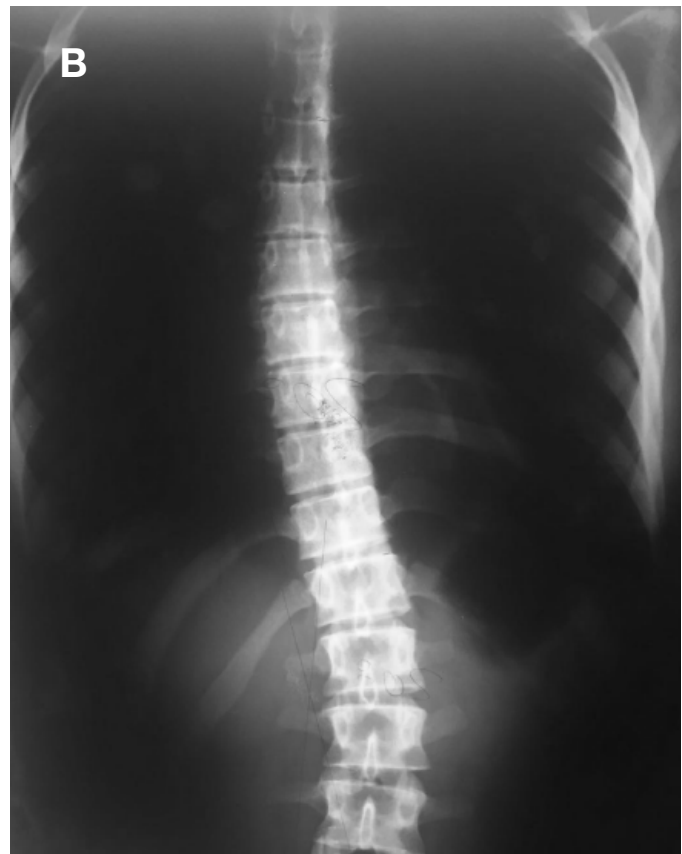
(A) Bethany Ward x-ray, posterior view, 2015; (B) Bibiana Badenes x-ray, anterior view, 1986.
